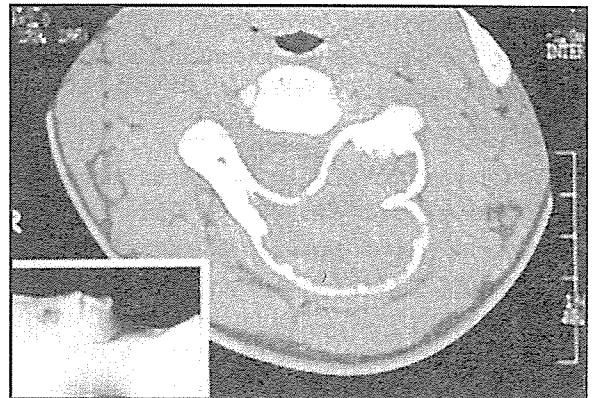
CT and 3D-CT of cervical spine demonstrating cystic cavitation of posterior elements of the cervical second vertebra (Case 2).
